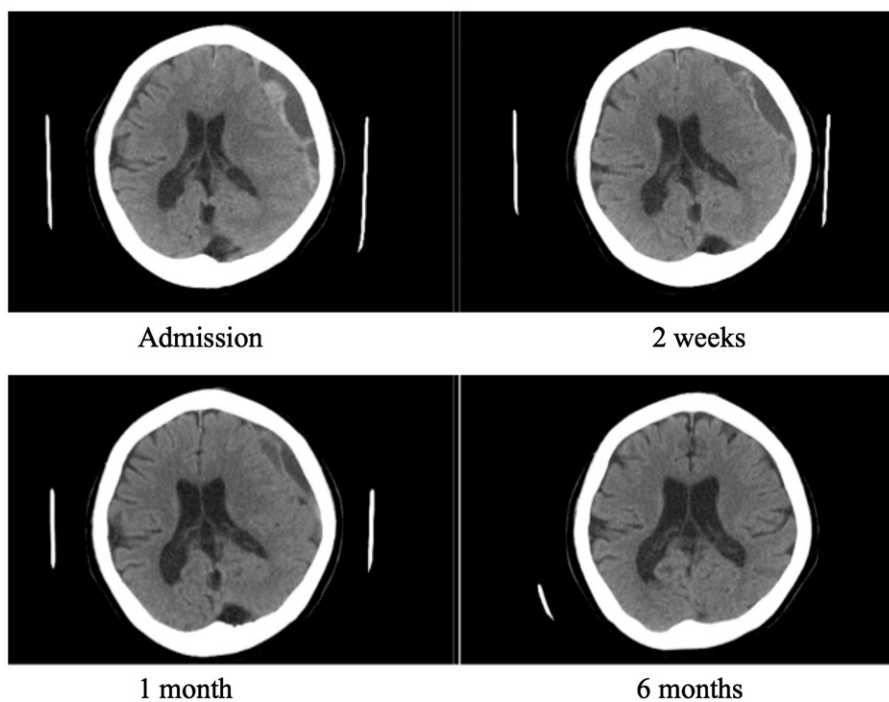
CT brain scan of a 70-year-old lady presented with frequent fall.
